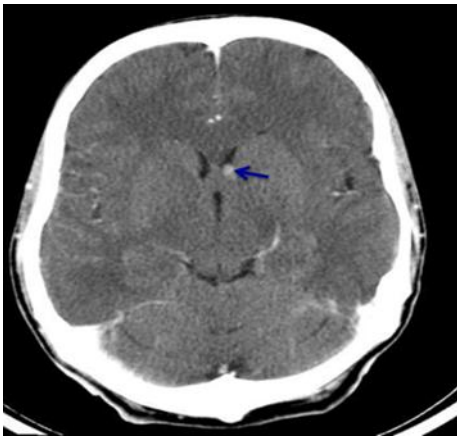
CT image of obstruction of the foramen of Monroe due to tuberous sclerosis
